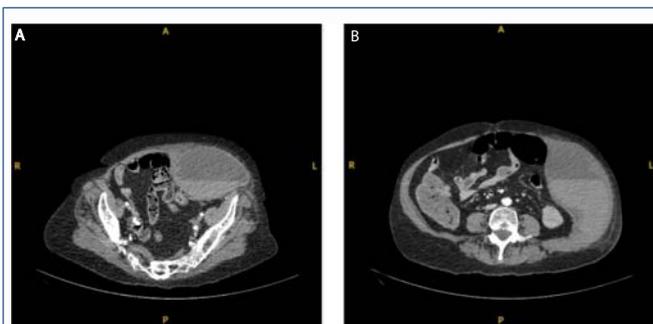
Cross sectional images of the CT scan A. at the origin of inferior mesenteric artery and B. the extent upwards at the splenic level.
